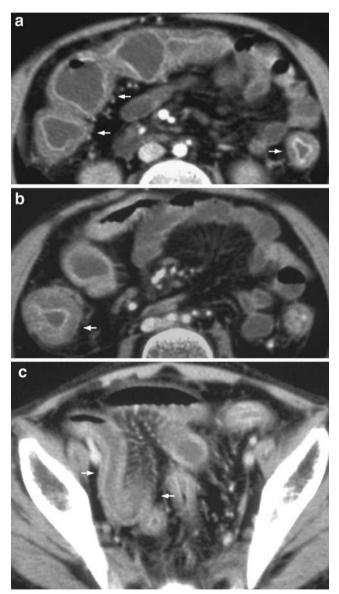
A 14-year-old child with CD. Contrast-enhanced CT images (single-slice scanner). Circumferential wall thickening of the large bowel (a, b) and the terminal and distal ileum (c). Mural stratification of bowel loops (target sign) is evident due to low attenuation of the oedematous submucosa (*arrows*). Fibrofatty proliferation separates the loops; the comb sign is also evident
